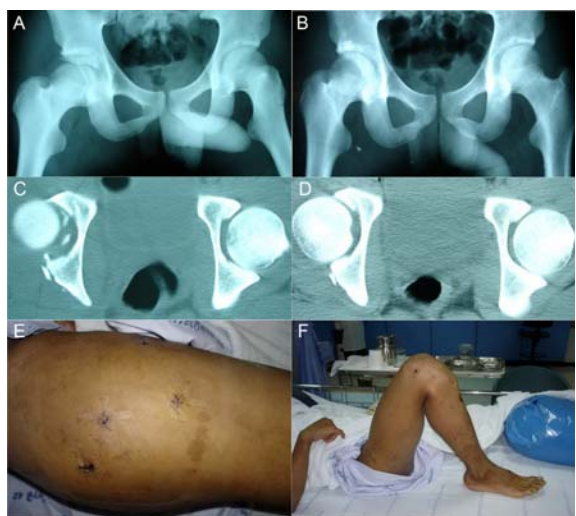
(A, C) Preoperative radiograph and CT scans demonstrating multiples loose fragments retaining in the hip joint. (B, D) Postoperative radiograph and CT scans reveal no obvious loose bodies. (E) Cosmetic appearance (F) Range of movement of the hip the 5th day postoperatively
